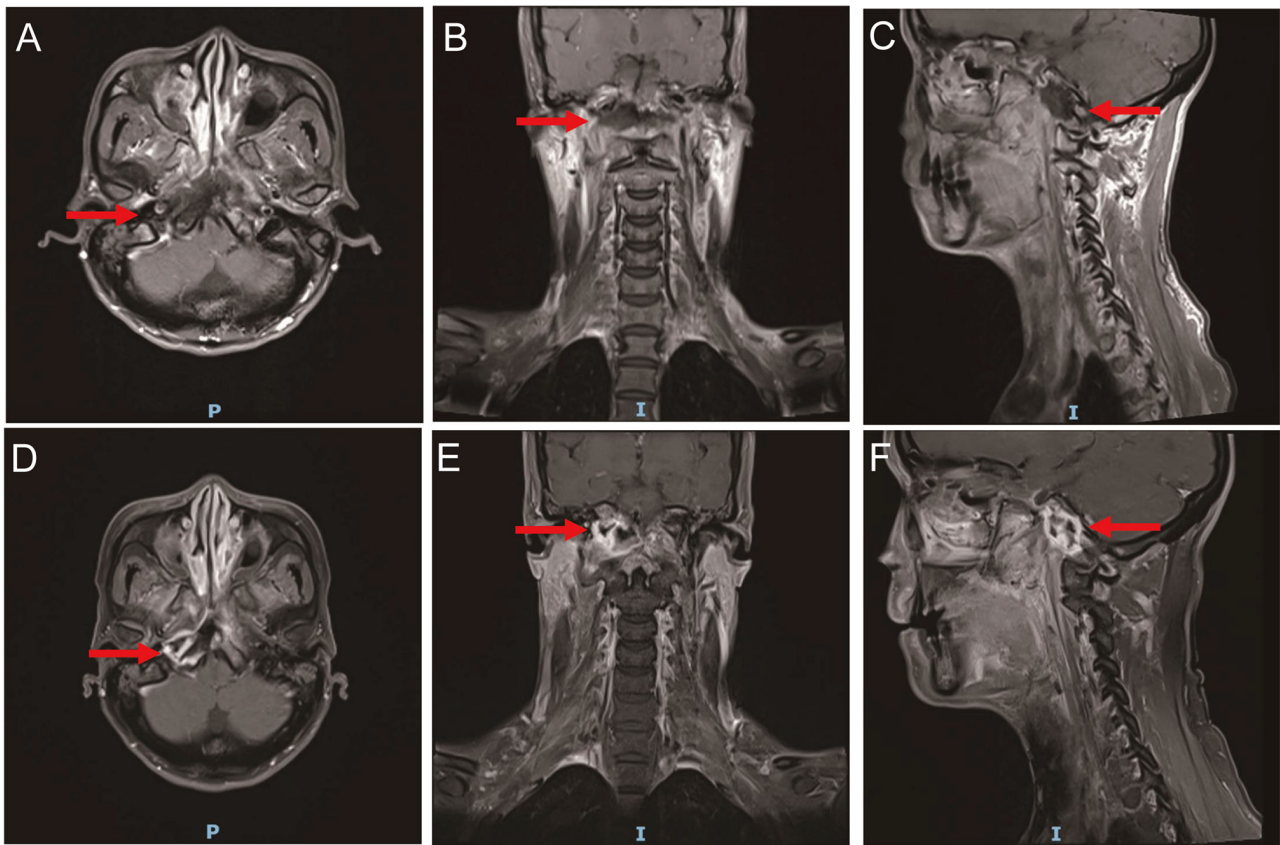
Comparison of the images obtained with MRI before and after treatment for case 2. (A-C) Pre-treatment images obtained with MRI and (D-F) post-treatment images obtained with MRI. MRI revealed that necrosis of the nasopharynx was replaced by new tissues that exhibited high signals on contrast enhanced T1-weighted CT (red arrow of D-F).
